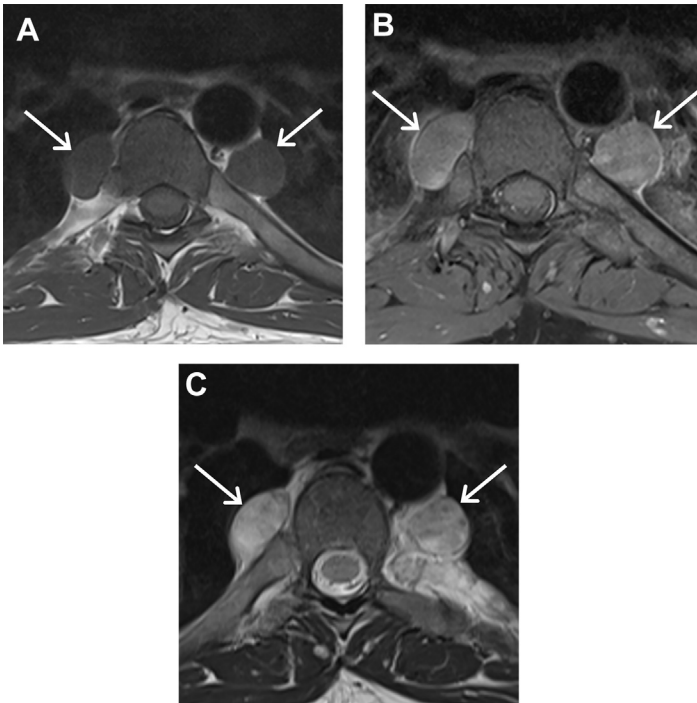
Neurofibromas in neurofibromatosis type 1. (A) Axial T1-weighted, (B) postcontrast T1-weighted, and (C) T2-weighted MR images of a patient with neurofibromatosis type 1 demonstrate multiple paravertebral neurofibromas (arrows) that enhance and show predominantly high T2 signal intensity although internal regions of low T2 signal also are present.
